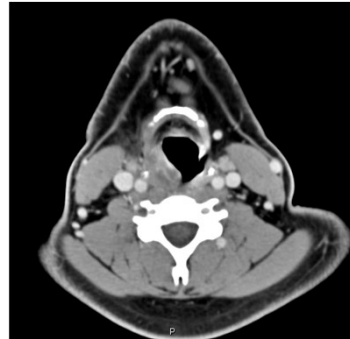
CT soft tissue of the neck with bilateral cervical lymphadenopathy and palatine tonsil edema.
